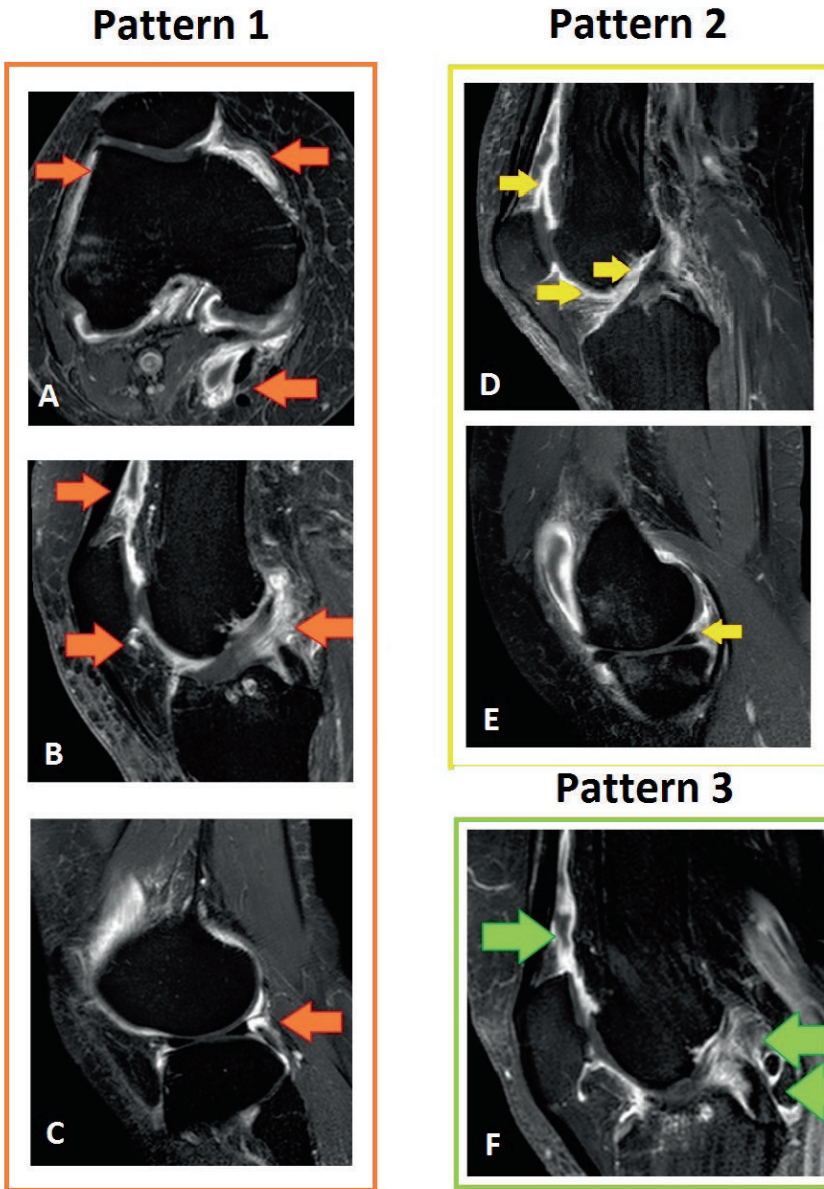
Gadolinium(Gd)-chelate enhanced T1-weighted images showing three synovitis patterns observed in knee osteoarthritis (OA) patients. Pattern 1 (A-C), A. Axial image showing synovitis at the medial parapatellar site, lateral parapatellar site and Baker cyst, B. Sagittal image with synovitis at the suprapatellar site, infrapatellar site and site adjacent to the posterior cruciate ligament (PCL), C. Sagittal image showing synovitis at the lateral meniscal site. Pattern 2 (D and E), D Sagittal image showing synovitis at the suprapatellar site, intercondylar site and site adjacent to anterior cruciate ligament (ACL), E. Sagittal image showing synovitis at the medial meniscal site. Pattern 3 (F), F. Sagittal image showing synovitis at the suprapatellar site, at the site adjacent to PCL and surrounding loose body (green arrowhead).
